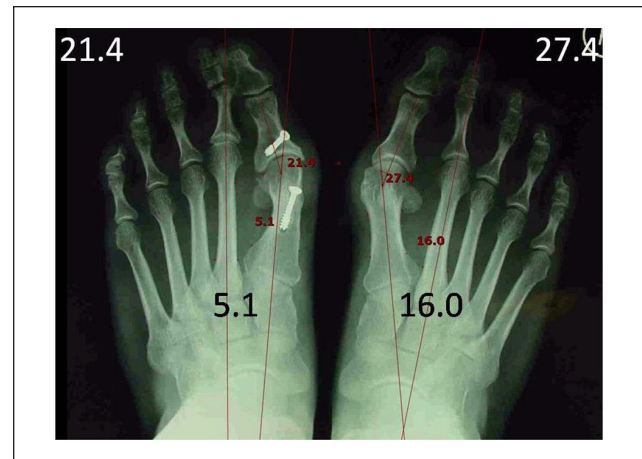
Standing full weightbearing radiograph showed left foot IMA of 5.1 and MPA of 21.4 degrees and right foot IMA of 16 degrees and MPA of 27.4 degrees. IMA, intermetatarsal angle; MPA, metatarsophalangeal angle.
